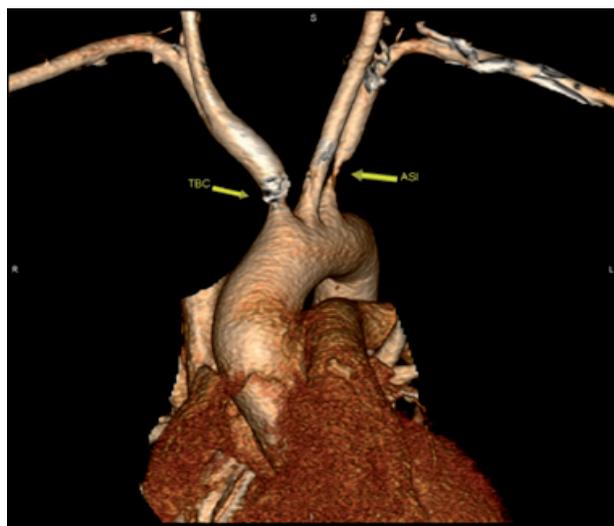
Follow-up CT angiography at 6 months of treatment.
